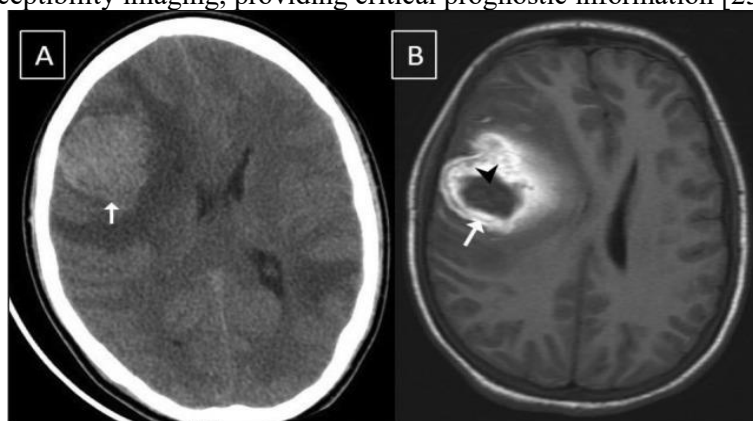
A 16-year-old boy developed altered sensorium followed by loss of consciousness. Plain CT scan (A) shows a hyperdense lesion (arrow) in the right frontoparietal region, with surrounding white matter edema and mass effect. Axial plain T1W MRI (B) at the corresponding level shows a hyperintense periphery (arrow) due to the presence of intracellular methemoglobin and central hypointensity (arrowhead) due to deoxyhemoglobin [25].
